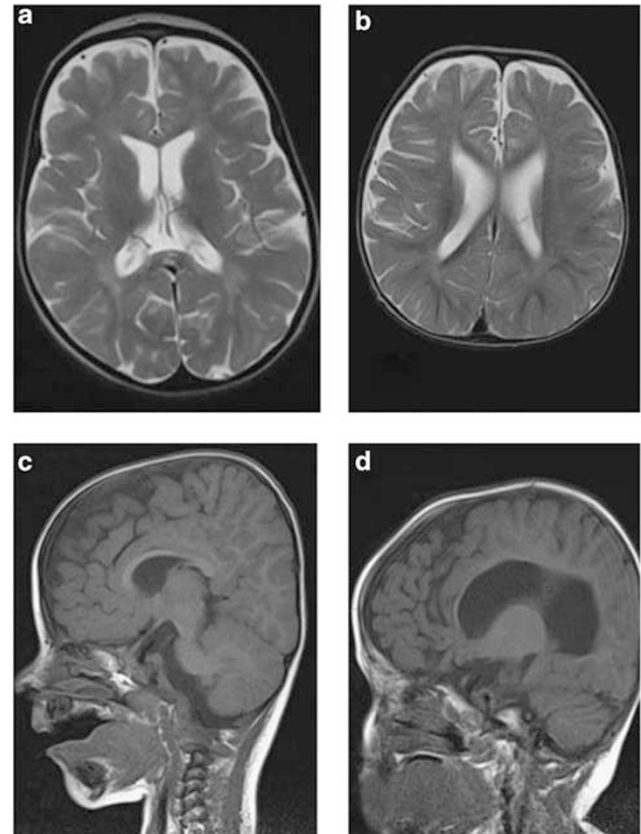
Mild abnormalities on MRI imaging of three patients. Cerebral MRI of patient 3 shows mild white matter changes on T1-weighted images (a; aged 4 years). Cerebral MRI of patient 5 shows delayed myelination (b; aged 19 months) on T1-weighted images. Cerebral MRI of patients 4 (c; aged 2 years) and 5 (d; aged 15 months) shows hypoplasia of the corpus callosum and frontal atrophy on T2-weighted images.
